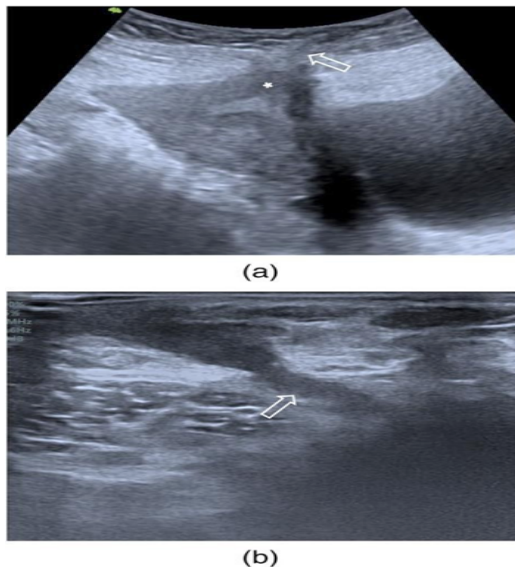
Transabdominal ultrasound in the sagittal plane (a) axial plane (b) showing a fistulous tract extending from the anterior body of the uterus.
